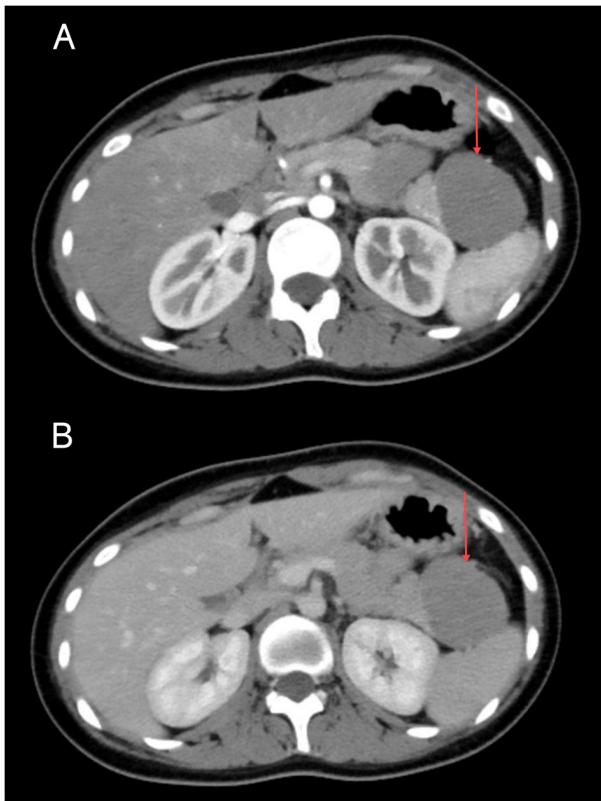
Radiological findings. (A) Enhanced CT showing low enhancement of the lesion in the arterial phase (arrow). (B) Enhanced CT showing low enhancement of the lesion in the venous phase (arrow). CT, computed tomography.
